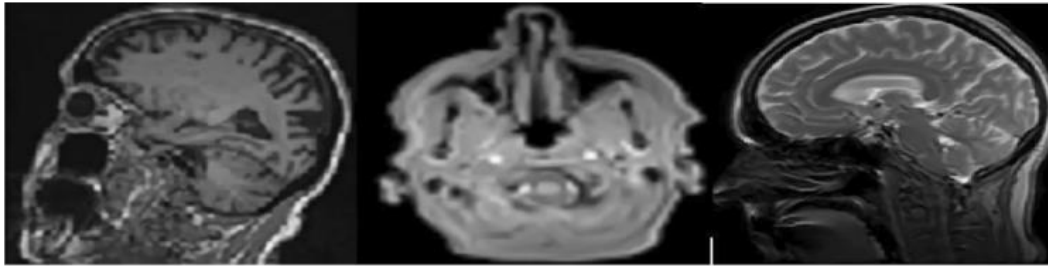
Slices of MR images: Accelerated Sagittal MPRAGE view, Axial Field Mapping view, and 3 Plane. Localizer view from left to right of AD patient
